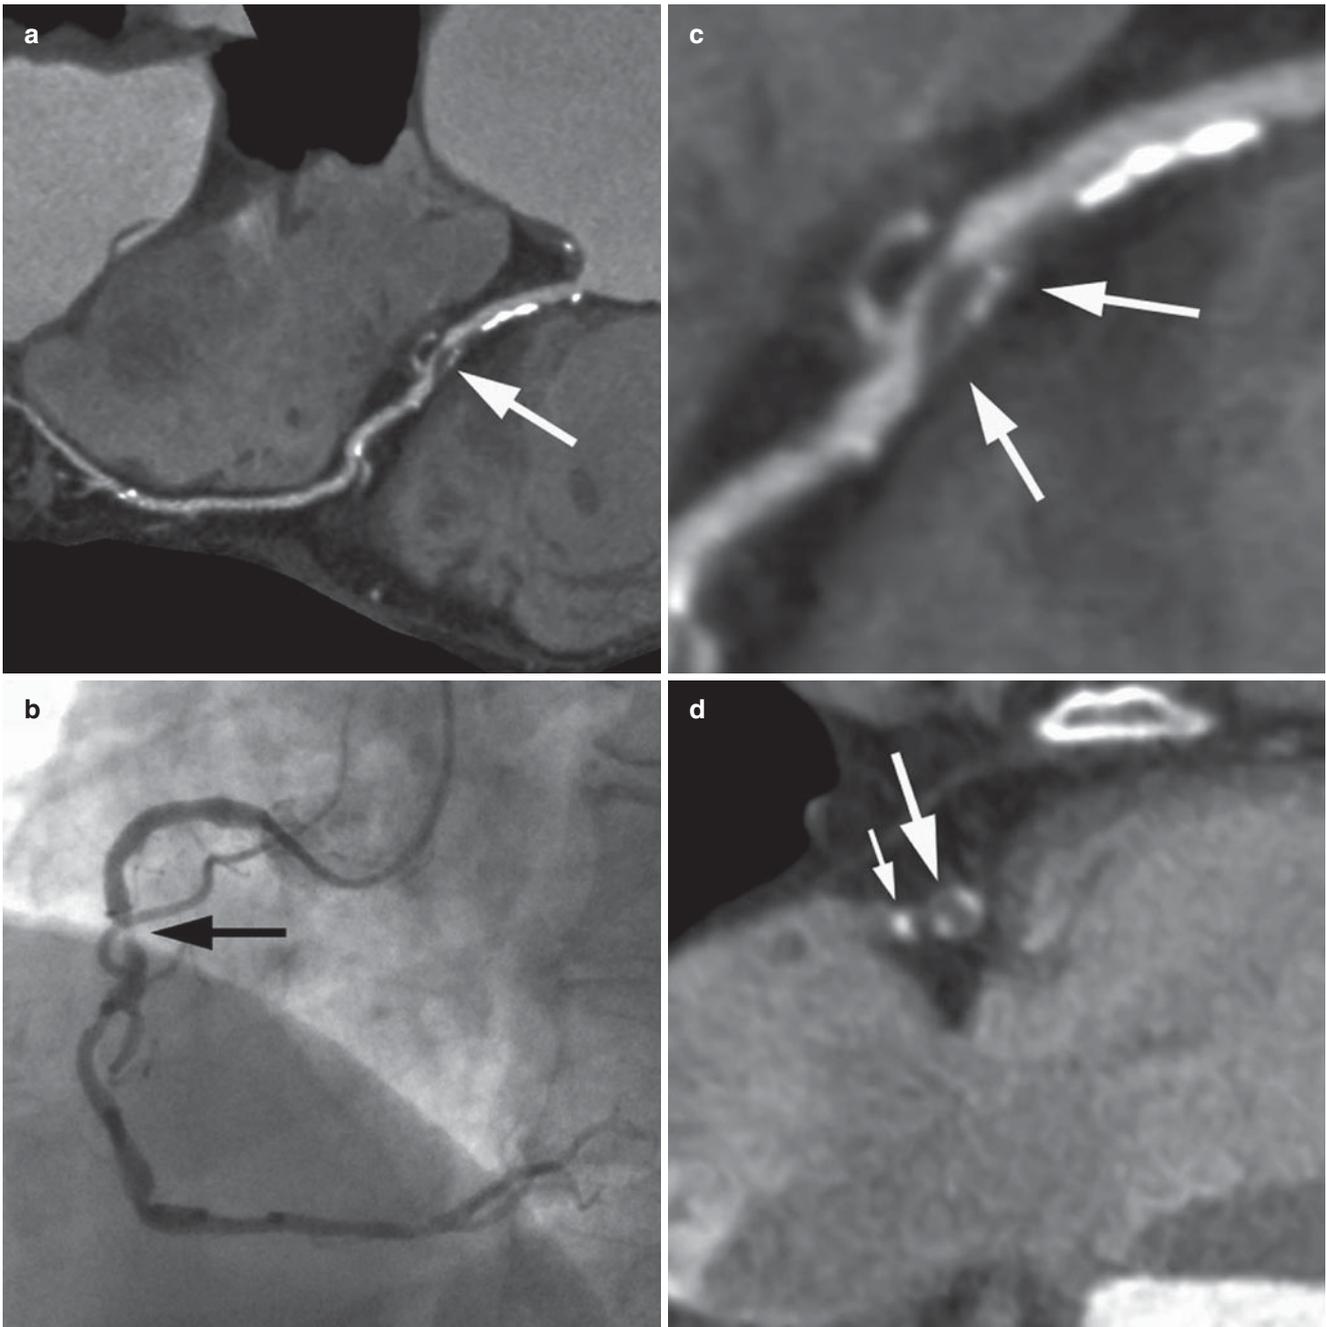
Coronary CT angiography in a patient with acute chest pain. (a) Curved multi-planar reconstruction of the right coronary artery. Besides some calcification, a luminal stenosis of the proximal right coronary artery is visible (*arrow*). (b) Corresponding invasive coronary angiography (*arrow* = stenosis). (c) In CT angiography, the lesion of the right coronary artery shows some characteristics that
